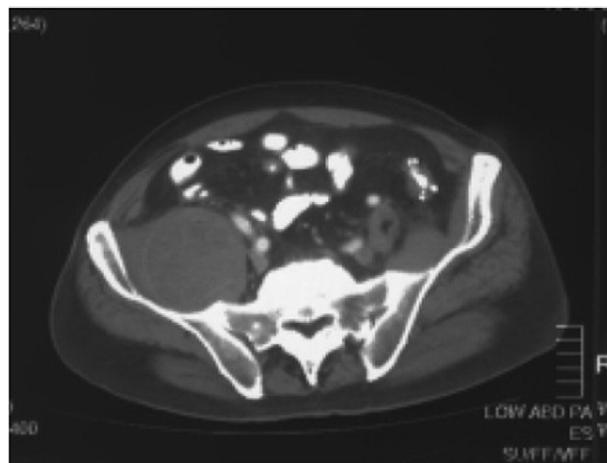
Abdominal computed tomography showing a large right retroperitoneal mass.
